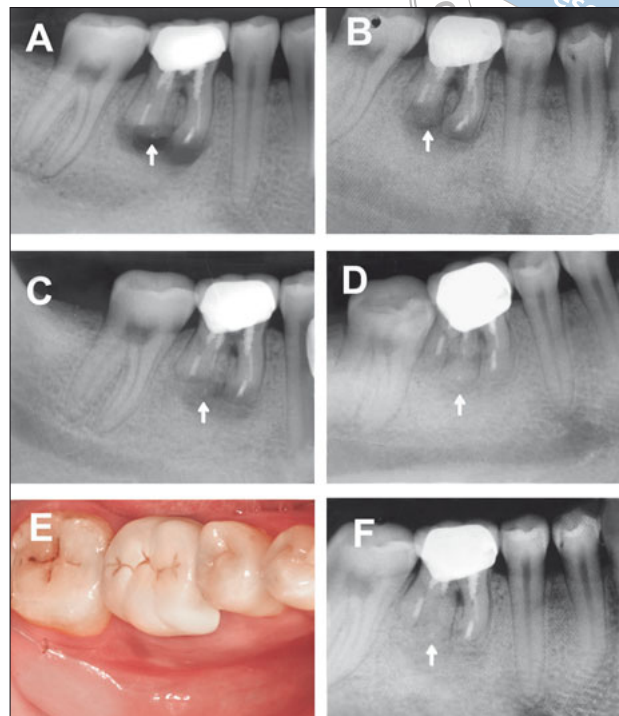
(A) Postoperative radiograph. (B) Periapical radiograph 3 months postoperatively. (C) Periapical radiograph 6 months postoperatively. (D) Periapical radiograph 9 months postoperatively. (E) Clinical image 15 months postoperatively. (F) Periapical radiograph 15 months postoperatively. (Arrow: DL root)
